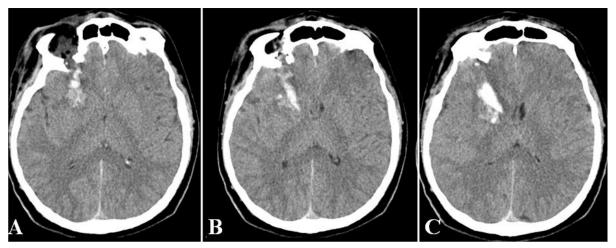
"Head CT-scan with: right orbital roof fractures (A, B). right frontal dilaceration and intracerebral hemorrhage (B, C) that respects the trajectory of the foreign body" (from *Turliuc et al., 2017*)
